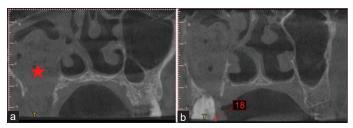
CBCT showing evidence of the presence of foreign body inside the sinus and Oroantral sinus with bone loss on the alveolar socket of 17
